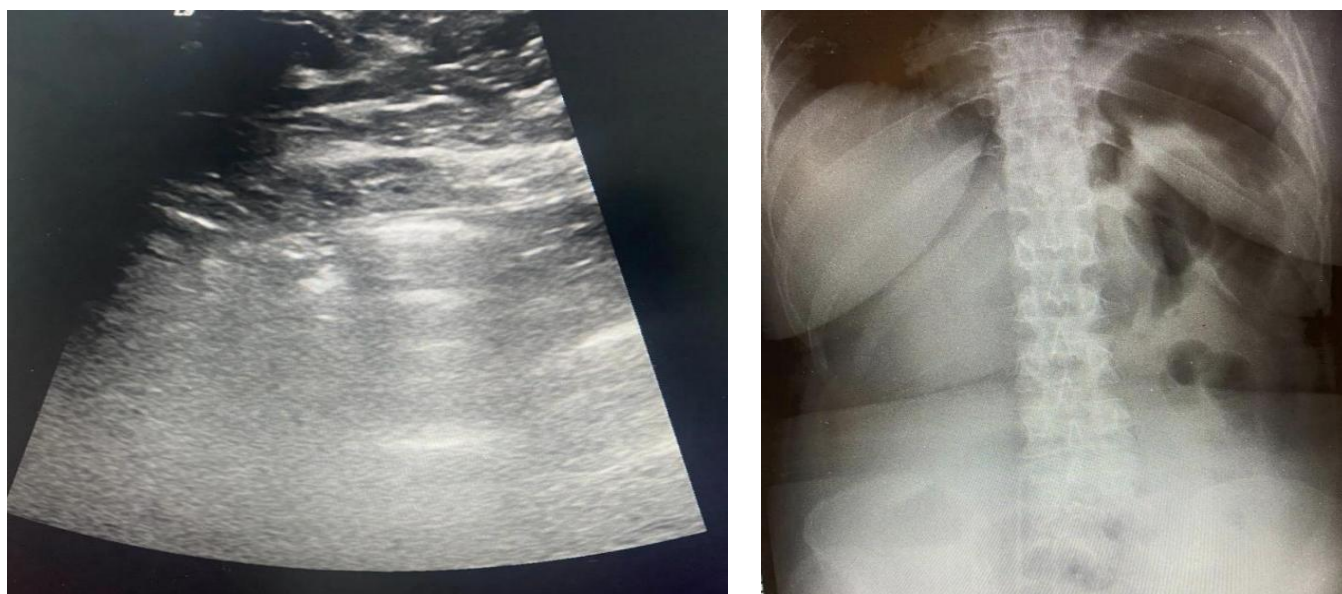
Ultrasound and X-ray images of post-surgical pneumoperitoneum of the same patient.
